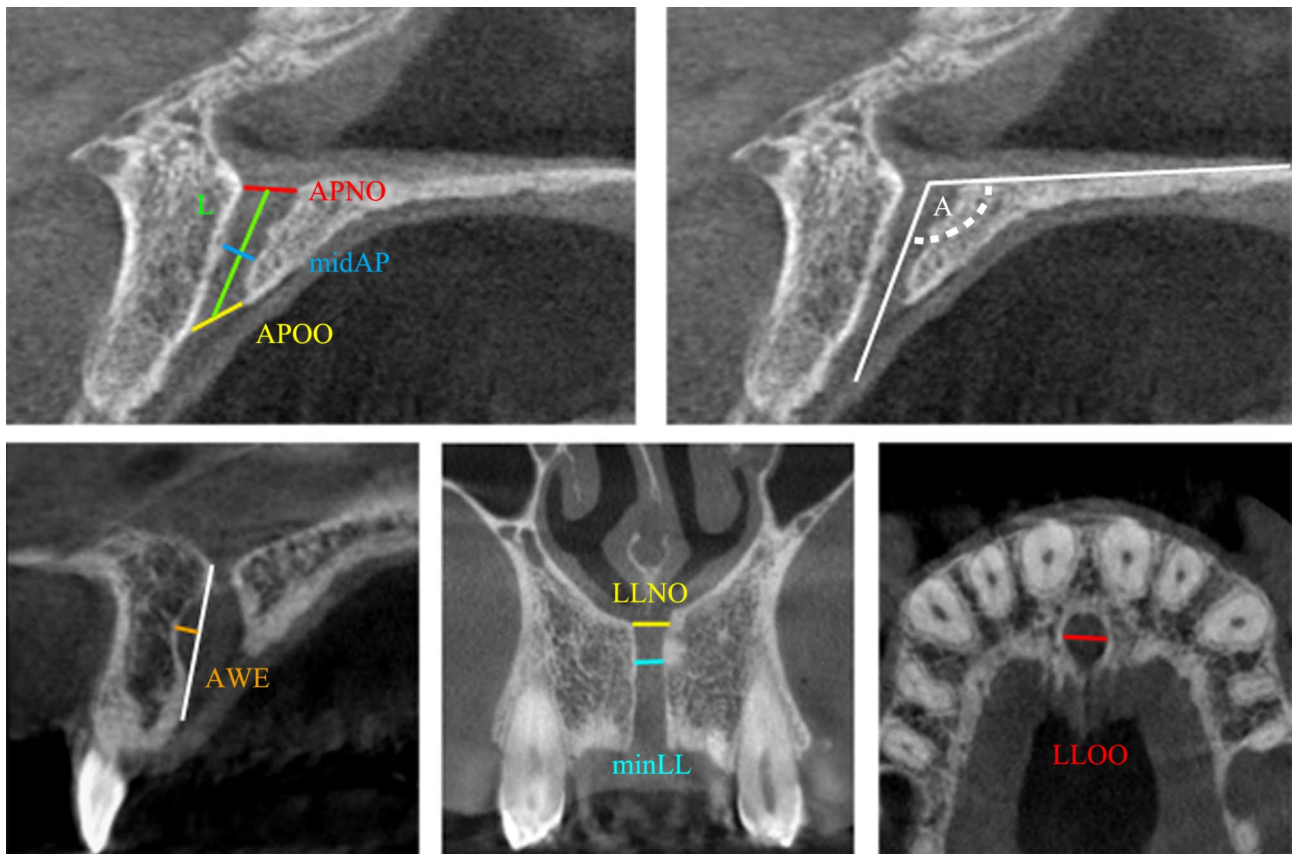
Morphological parameters of the nasopalatine canal measured on reference CBCT section images. A, B. Measurements in a reference sagittal plane: APNO (in mm) - anteroposterior diameter of the nasal opening, APOO (in mm) - anteroposterior diameter of the oral opening, midAP (in mm) - mid-level anteroposterior diameter of the canal, L (in mm) - length of the canal, A (in degrees) - the angle between the canal axis and the nasal floor. C. AWE (in mm) - anterior wall expansion measured on the same sagittal image. D. Measurements in a reference coronal plane: MLNO (in mm) - mediolateral diameter of the nasal opening, minML (in mm) - minimum mediolateral diameter. E. Measurements in a reference axial plane: MLOO (in mm) - mediolateral diameter of the oral opening
